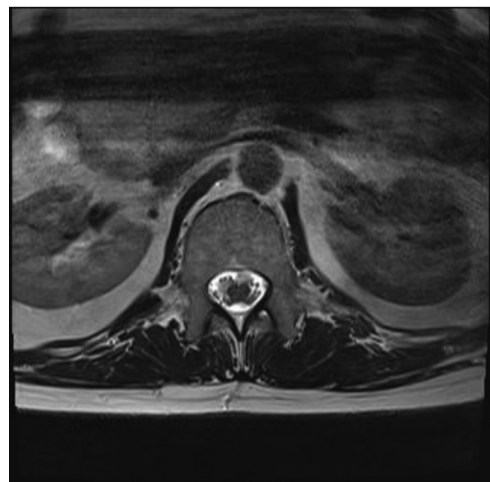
Axial post contrast MRI T2 of lumbar spine showing dural lesion at level of L1.
